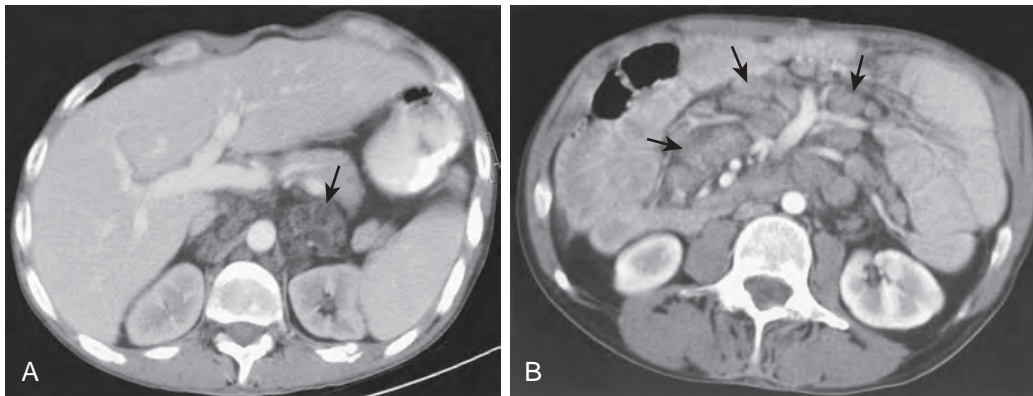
Lymphadenopathy in Whipple's disease. A. CT through the liver shows low-attenuation lymphadenopathy in the retrocaval, retrocrural and left para-aortic (arrow) regions. B. An image caudal to A shows marked mesenteric lymphadenopathy (arrows) of more uniform and higher attenuation.
